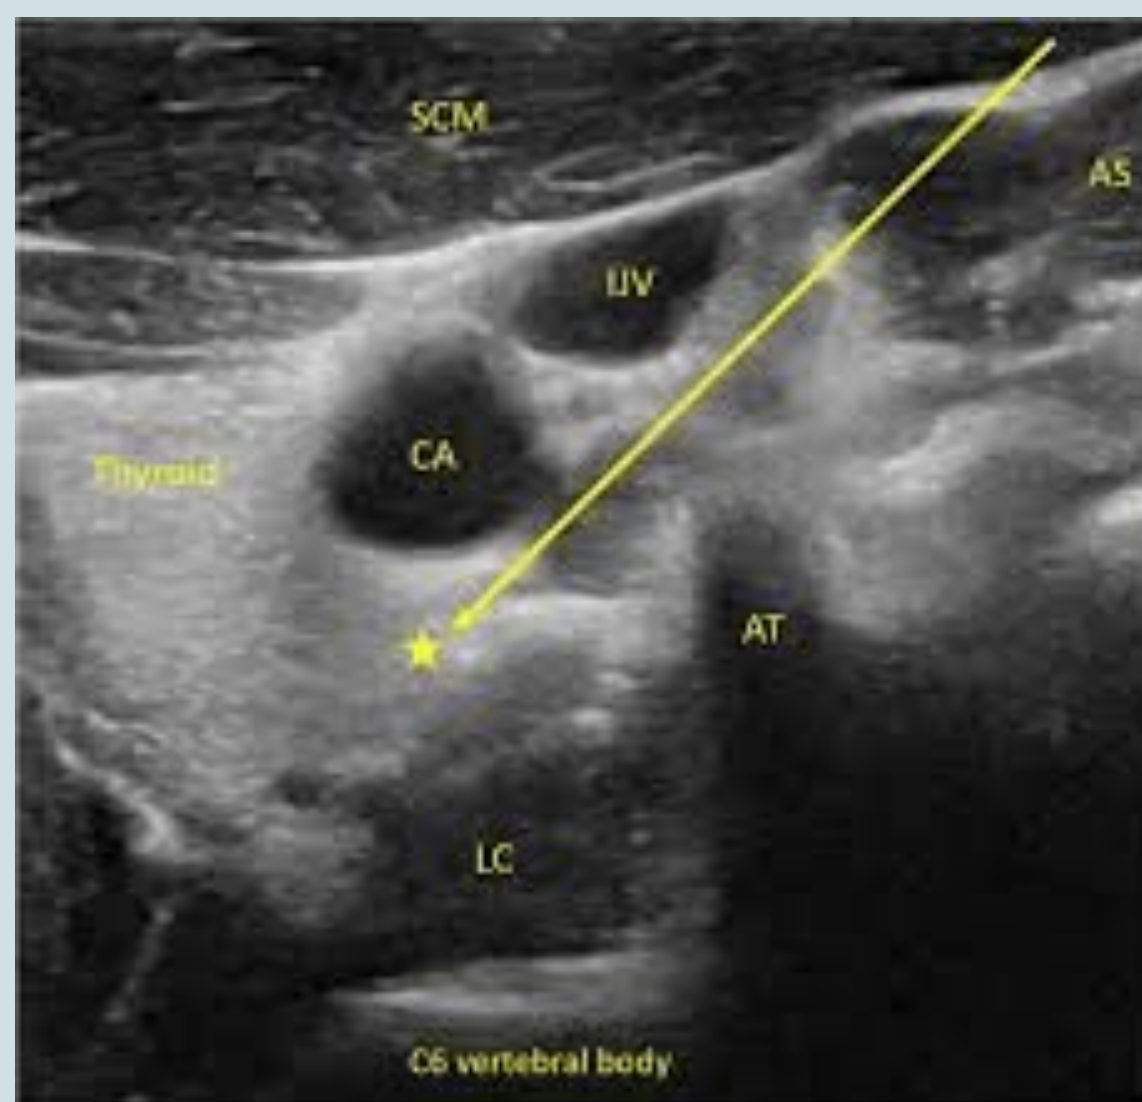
Ultrasound of stellate ganglion block anatomy with needle trajectory
